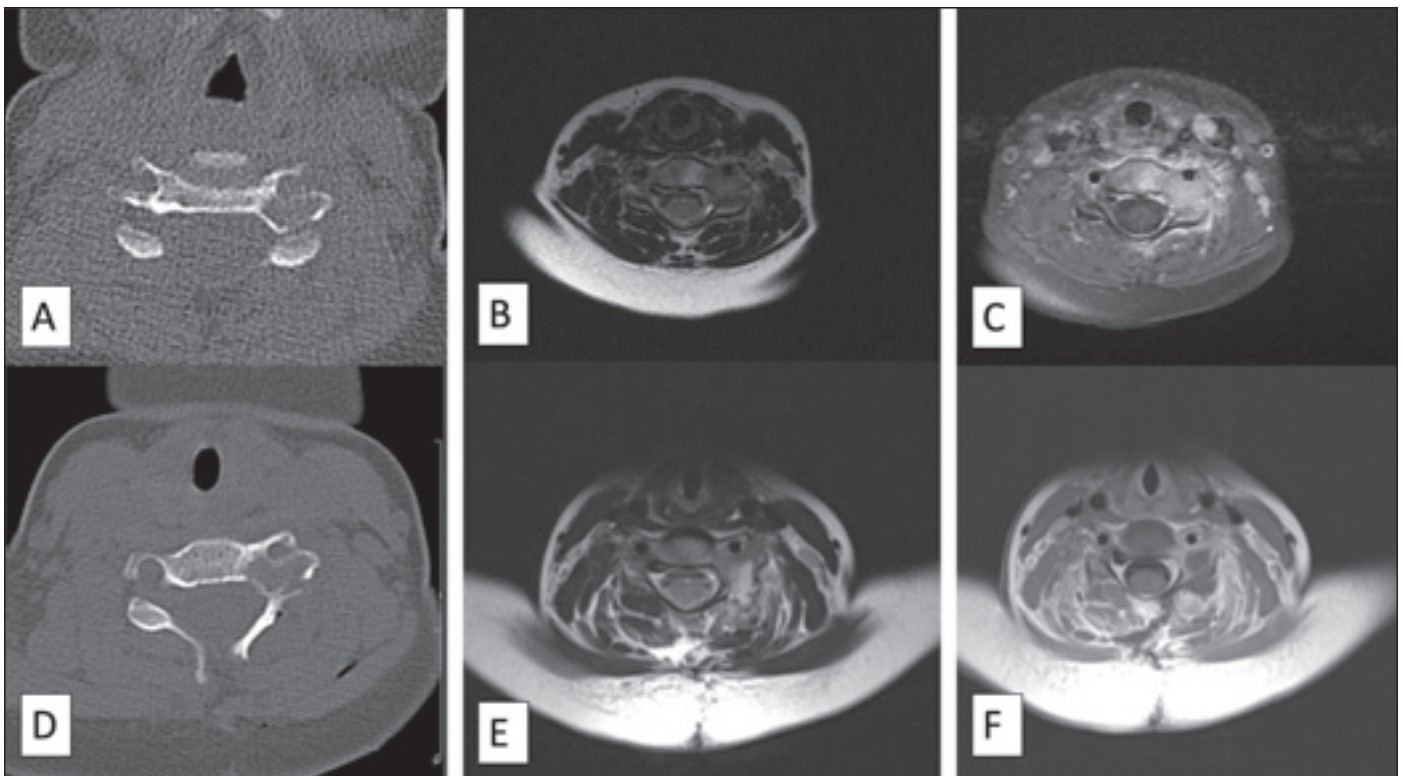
Images of the patient with recurrent osteoblastoma (Patient 11) before recurrence: (A) preoperative axial CT image; (B) preoperative axial T2-weighted MRI image; (C) preoperative axial postcontrast T1-weighted MRI image; (D) postoperative axial CT image; (E) postoperative axial T2-weighted MRI image; (F) postoperative axial postcontrast T1-weighted MRI image.
